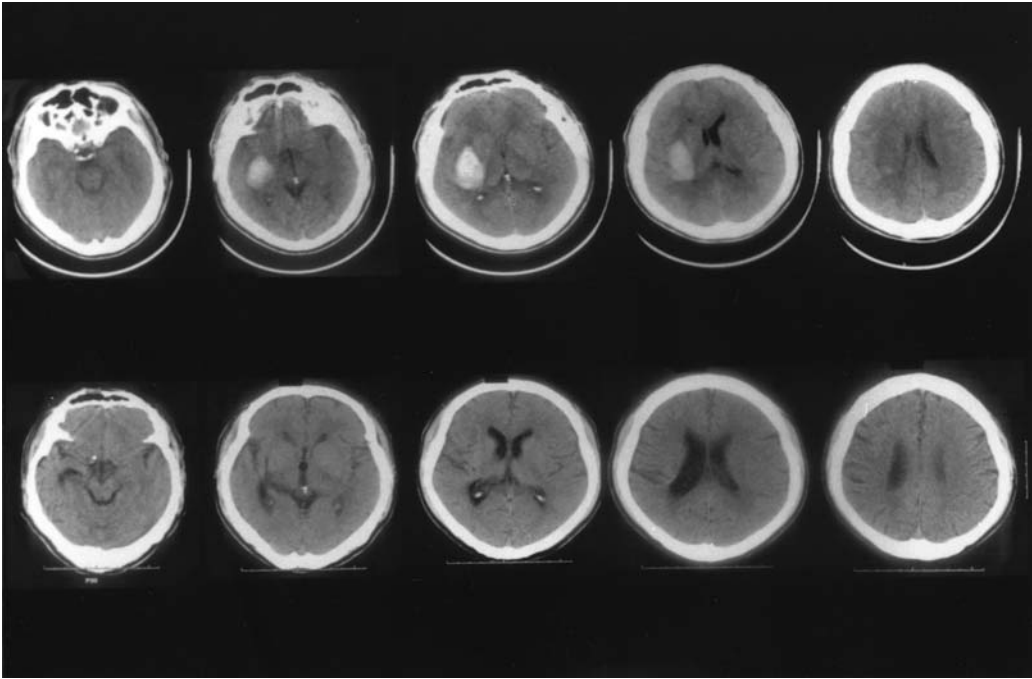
Computed tomographic scans of Pt. 3 with excellent performance on the Copying Words on the initial examination, with right putaminal hemorrhage. Top: CT scan slices where hemorrhage was present at 1 day poststroke; the hemorrhage involved the putamen with posterior extension into the posterior limb, internal capsule. Bottom: CT scan slices obtained at 65 months poststroke.
